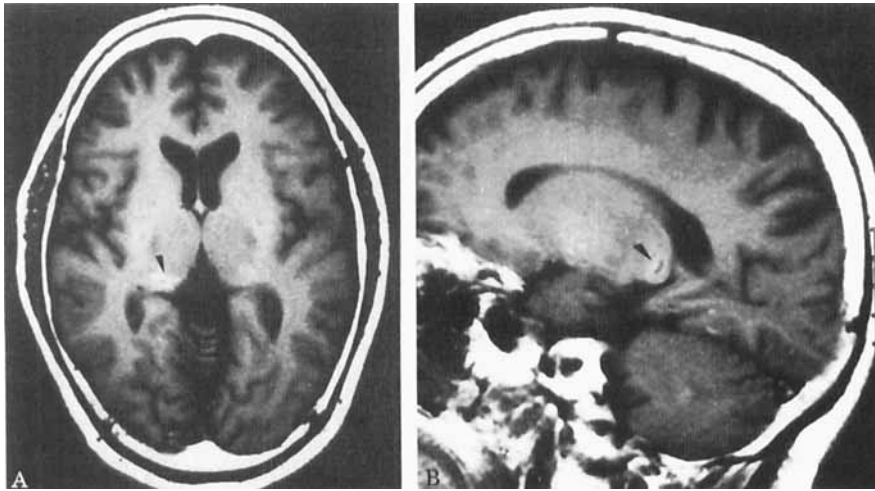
Brain MRIs show areas of central isointensity with a rim of hyperintensity (arrowheads) on the T1-weighted images (A, axial; B, parasagittal) in the right posteroinferior thalamus, including the medial geniculate body. Slice thickness: 8 mm, and gap 2 mm.
